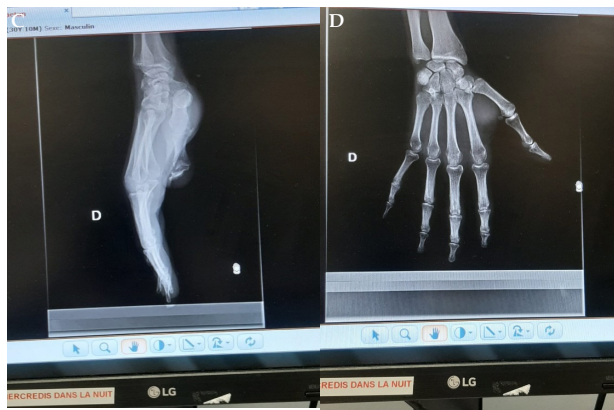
Right index finger anteroposterior (C) and lateral (D) radiographs at 6-weeks follow-up demonstrate a well reduced index MCP joint.
